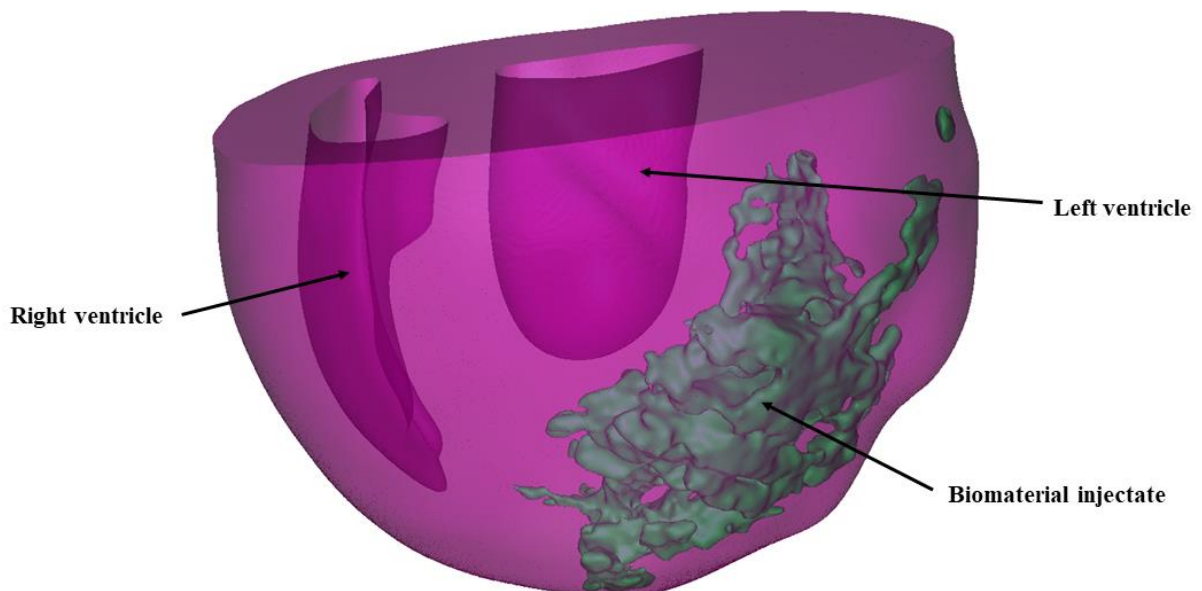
Biventricular geometry developed from μ CT scan images in Simpleware. The LV, RV and a detailed dispersion of injectate are shown.
